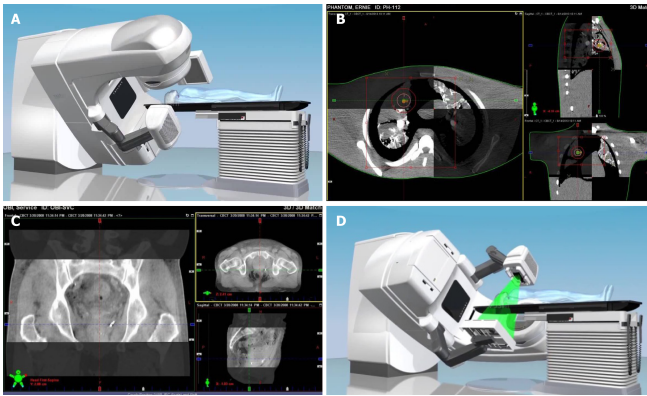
Cone-beam computed tomography. A: CBCT device; B: Chest view; C: Pelvic view; D: Image-guided radiotherapy [18].
